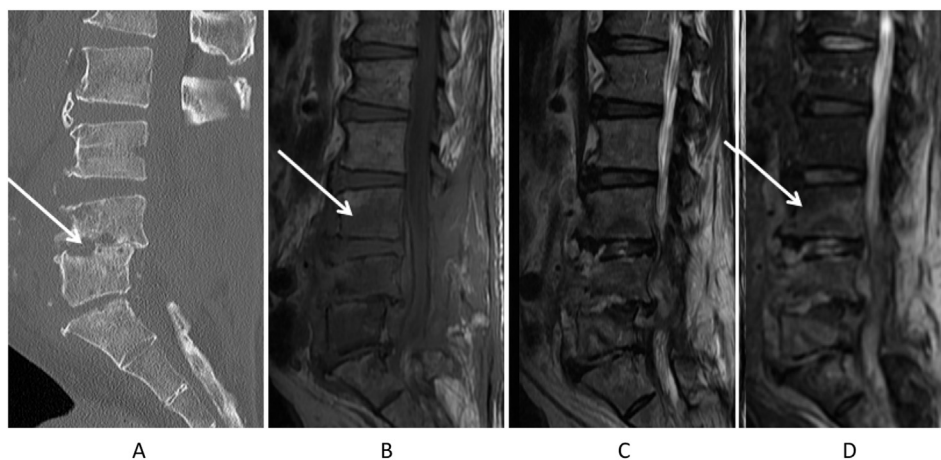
Pyogenic Spondylodiskitis: 71 year old male with prior spinal Tuberculous infection with subsequent spinal decompression presenting with worsening back pain, fever, and lower extremity weakness 4 weeks after surgery. *Staphylococcus aureus* was the causative organism. A) Sagittal CT demonstrates destructive change of the endplates at the L4–L5 level with intervertebral disk height loss and destruction with retrolisthesis of L4 on L5. B) Sagittal T1-weighted image shows hypointense signal in the L3, L4, and L5 vertebral bodies with edema infiltrating the expected fatty marrow signal. C) Sagittal T2-weighted image demonstrates ill defined hyperintense signal in the L3, L4, and L5 vertebral bodies with hyperintense signal in the L4–L5 intervertebral disk space and surround paraspinal soft tissues. D) Sagittal T2/STIR sequence better demonstrates the edema and inflammatory change within the L3, L4, and L5 vertebral bodies, L3–L4 and L4–L5 intervertebral disks, and paraspinal musculature. The suppression of the fatty marrow in the more normal L1 and L2 vertebral bodies allows for better sensitivity to detect edema when compared to the T2-weighted sequence (C).
